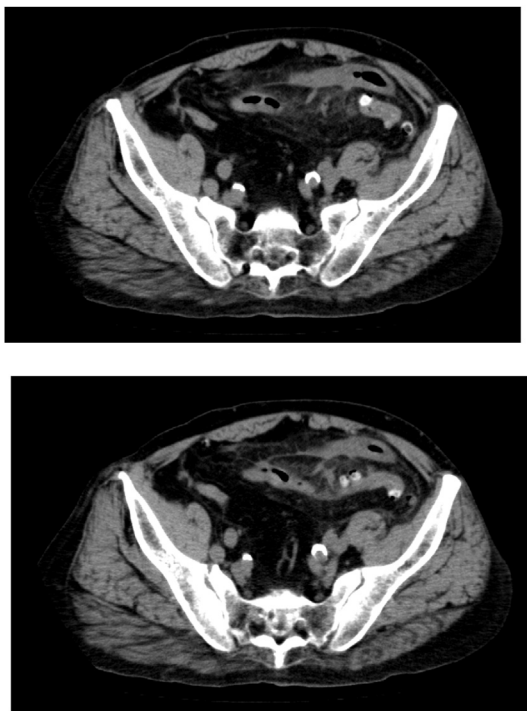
Computed tomography revealed ascites, free air in the abdominal cavity, multiple diverticula of the sigmoid colon, as well as increased fat tissue surrounding the sigmoid colon.
